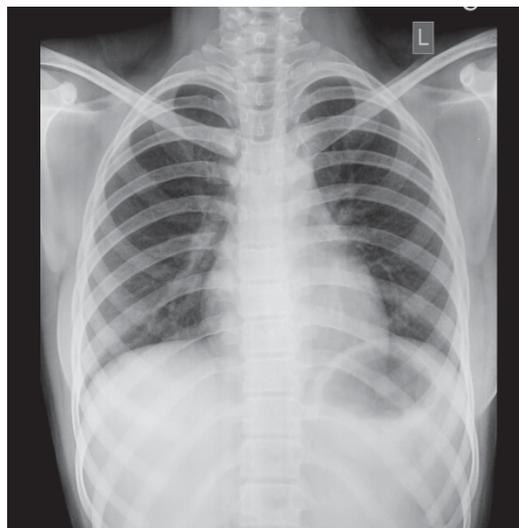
Chest X-ray PA view of the patient with no obvious pleuro-parenchymal disease
